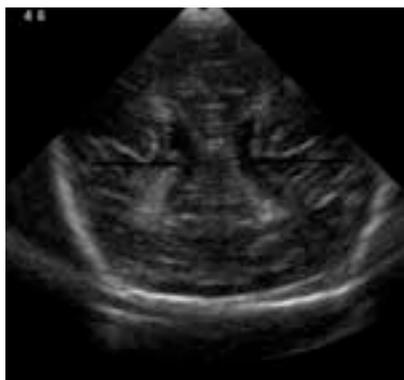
Head ultrasound performed at 4 hours of life demonstrating bilateral germinal matrix hemorrhage with ventriculomegaly (arrows).
